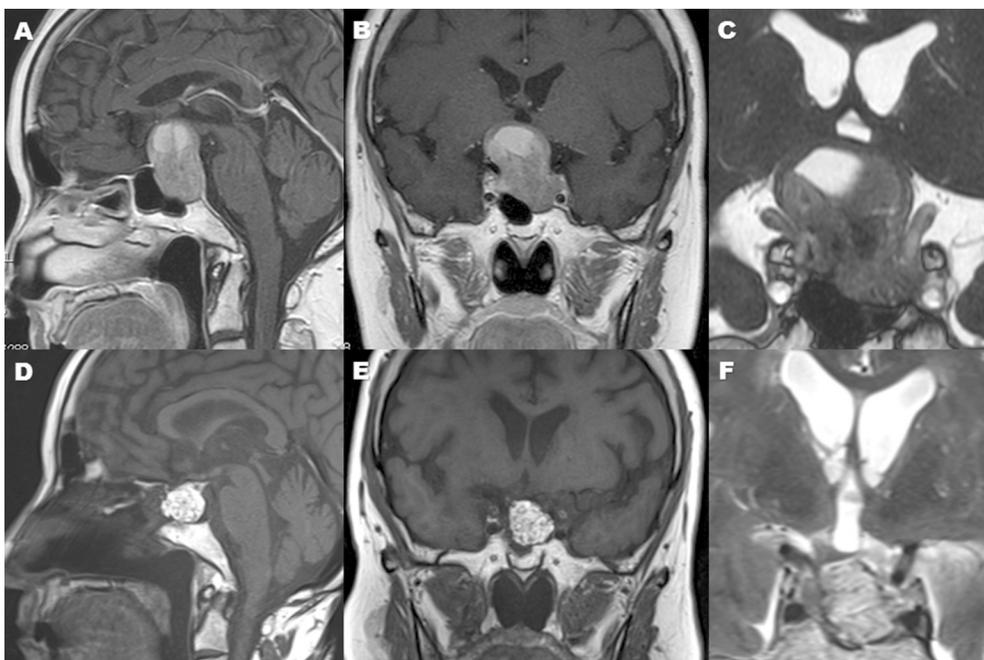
A: a preoperative mid-sagittal section of gadolinium-enhanced T1-weighted MR imaging shows a pituitary macroadenoma with suprasellar extension. B: a preoperative coronal section of gadolinium-enhanced T1-weighted MR imaging shows the macroadenoma partially involving the intradural segment of the right internal carotid artery. C: a coronal section of T2-weighted MR image demonstrates the markedly compressed optic chiasm by the macroadenoma. D: a postoperative sagittal section of precontrast T1-weighted MR image shows gross total resection of the macroadenoma and intrasellar inserted adipose tissue. E: intrasellar placement of the adipose tissue prevents empty sella after adenomectomy. F: optic pathway decompression is achieved.
